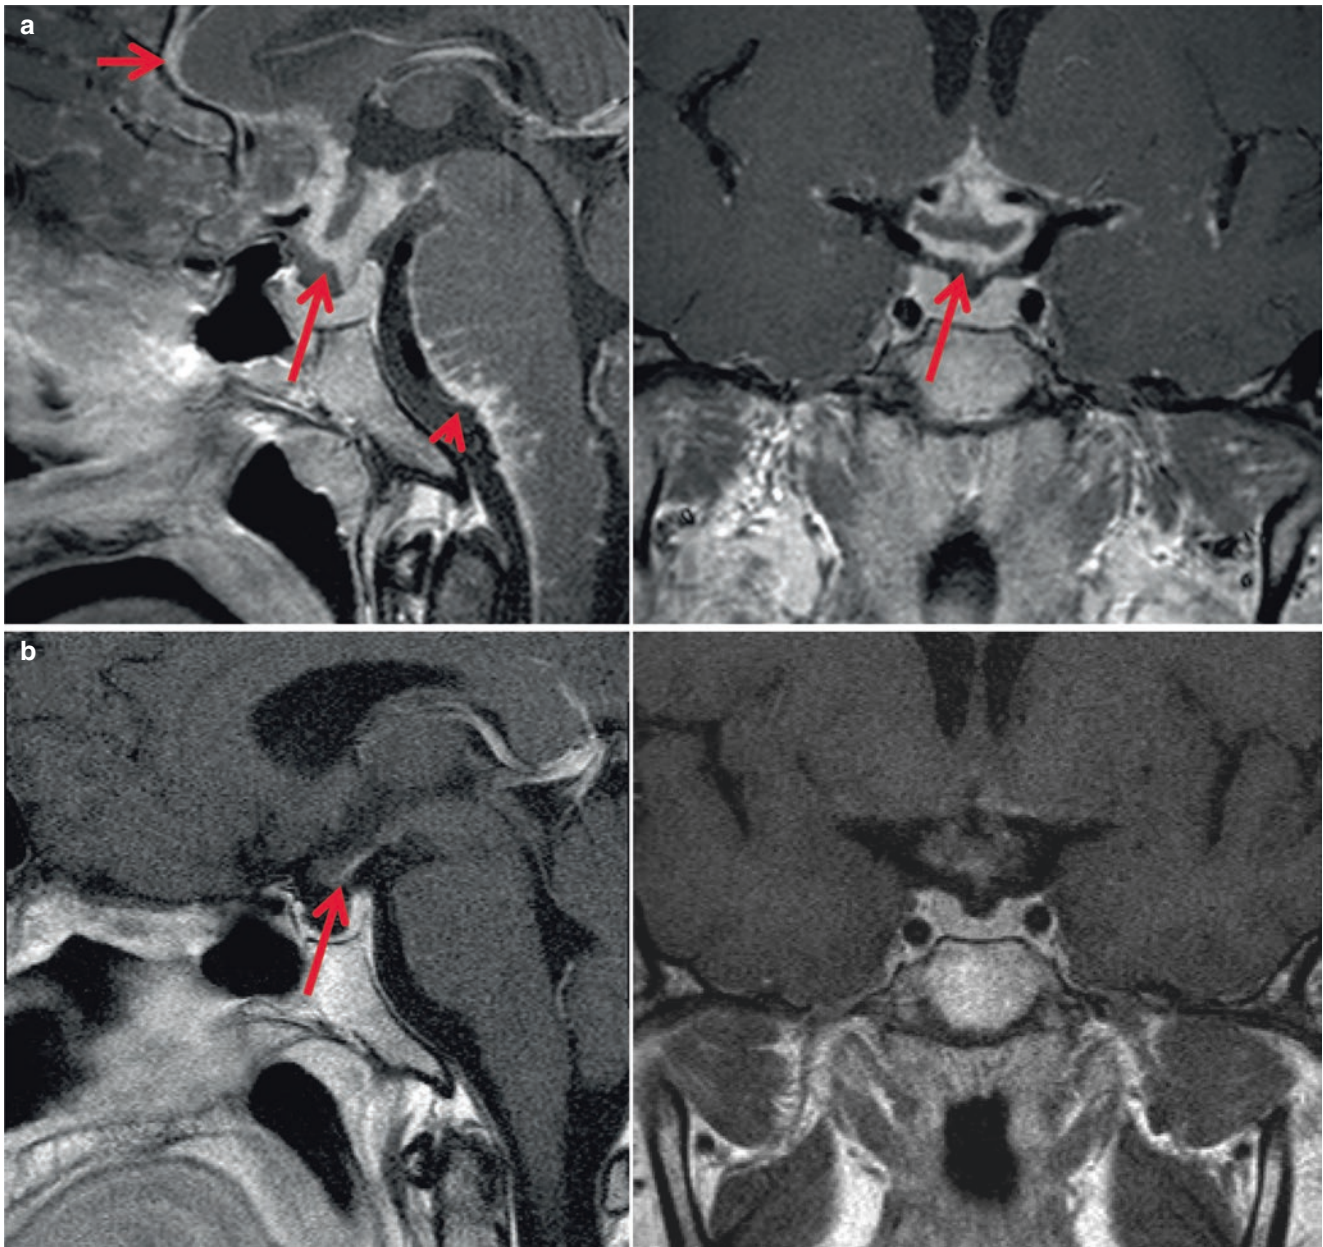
Magnetic resonance imaging (MRI) of the brain of a 32-year-old man with central nervous system (CNS) biopsy-proven definite neurosarcoidosis. The patient was treated with oral glucocorticoids, azathioprine, and methotrexate but progressed. (a) Despite treatment for 2 years with the above midsagittal and coronal T1-weighted images after gadolinium contrast demonstrated significant, progressing nodular leptomeningeal enhancement surrounding the optic chiasm and pituitary stalk (arrow), brainstem (arrowhead) including the cerebellopontine angle and upper cervical spinal cord and the interhemispheric fissure (horizontal arrow). (b) Midsagittal and coronal T1-weighted
